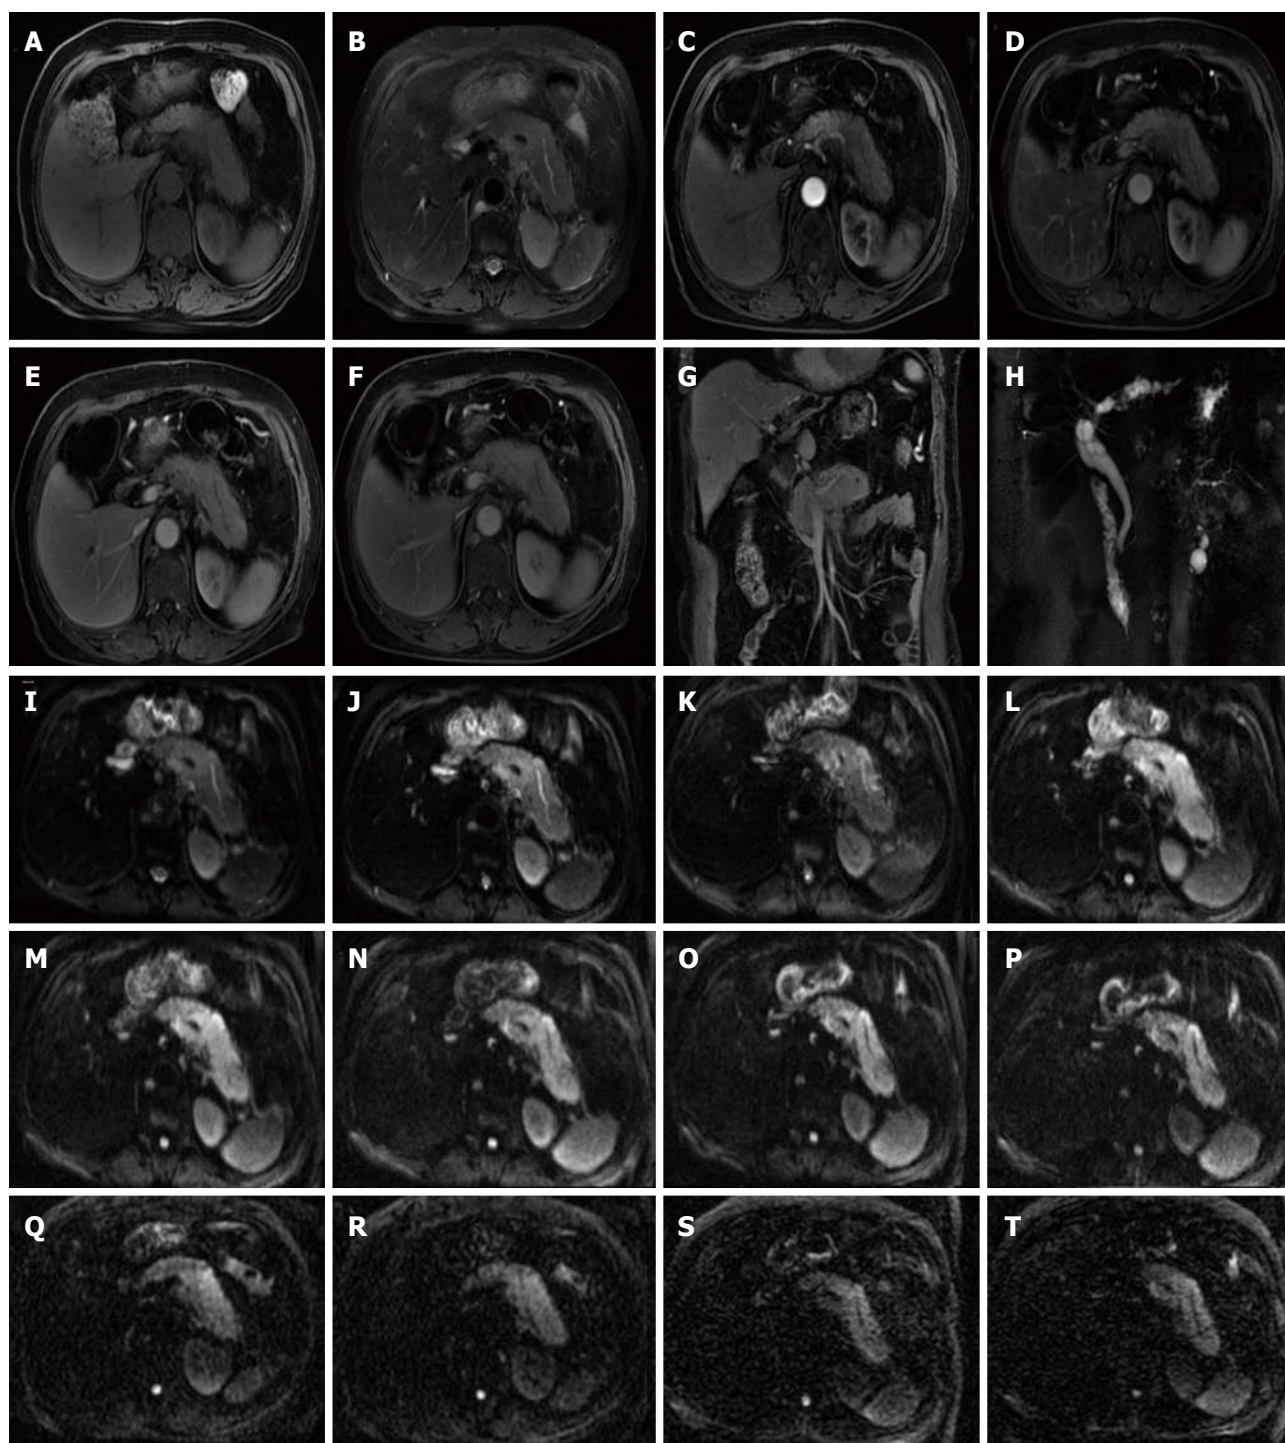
Images in a 52-year-old man with a focal lesion in the body and tail of the pancreas. MR imaging suggests that it is a malignancy. A: Axial T1-weighted fat-suppressed gradient-echo MR image; B: Axial T2-weighted fat-suppressed fast spin-echo MR image; C-G: Axial and coronal slab three-dimensional liver acquisition with volume acceleration dynamic contrast-enhanced; H: MRCP shows the dilated main pancreatic duct in the body and tail of pancreas; I-P: Multi-b DWI imaging ($b = 0, 50, 100, 300, 500, 800, 1000$ and 1500); DTI ($b = 500$ and 800) using 30 diffusion gradients directions; S and T: DKI ($b = 1500$ and 2000) using 30 diffusion gradients directions. MR: Magnetic resonance; DWI: Diffusion weighted imaging; DKI: Diffusion kurtosis imaging; MRCP: Magnetic resonance cholangiopancreatography.
